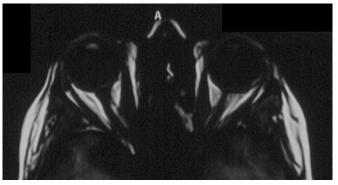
Axial T1-weighted brain magnetic resonance imaging demonstrating enlargement of the medial recti bilaterally in a patient with thyroid eye disease.
